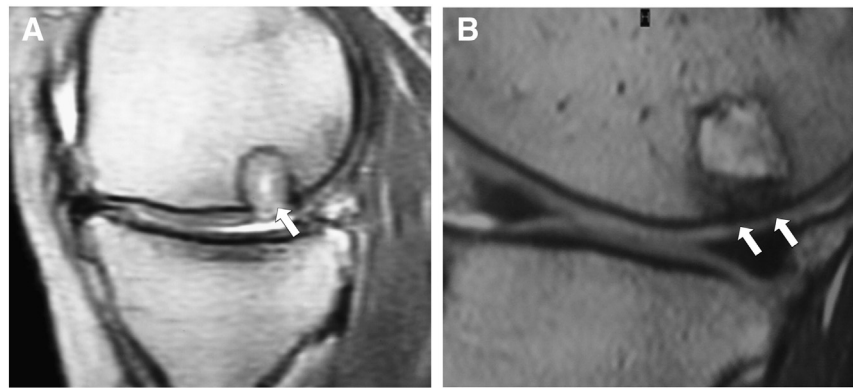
The subchondral lamina was rarely restored with the TruFit plugs. (A) In 48 cases, the subchondral lamina (arrow) was not restored, as can be clearly seen in this MRI view. (B) In only 9 cases, the subchondral lamina (double arrow) was observed in continuity with the host tissue.
